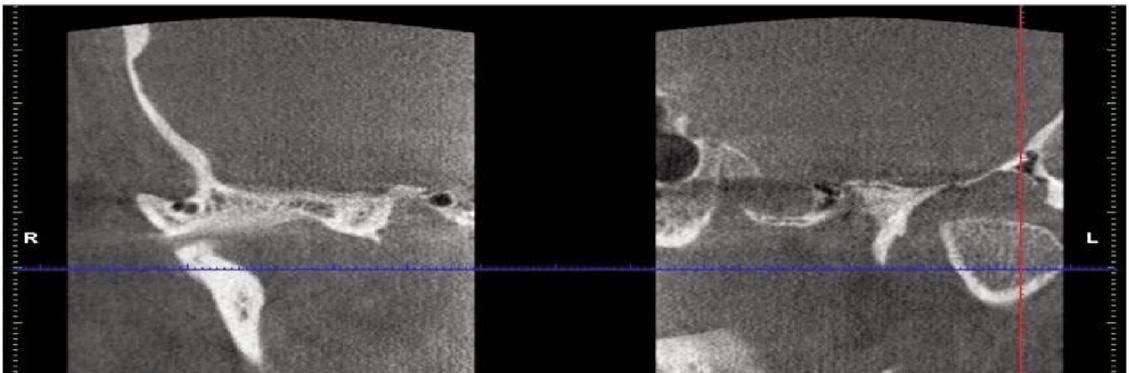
X-ray revealed an enlargement of the left mandibular joint process head. This proved the process of collum mandibulae on the left side.
